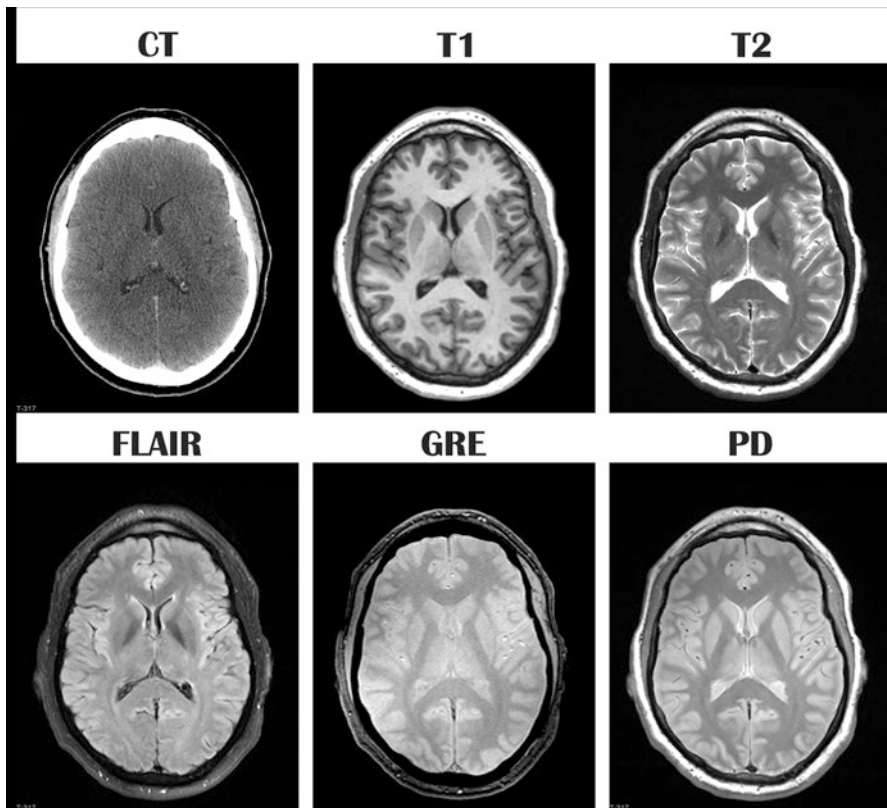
The images are all from the same individual and all performed at approximately the same level in a 45-year-old male control with no abnormalities. *CT* computed tomography, *T1* T1-weighted anatomical MRI with distinct white-gray matter boundaries, *T2* T2-weighted MRI where the hyperintense (white) signal indicates CSF or higher water content, *FLAIR* fluid-attenuated inversion recovery MRI sequence that is best in detecting abnormal white matter, *GRE* gradient-recalled echo that is particularly sensitive to blood by-products like hemosiderin but what is referred to as susceptibility-weighted imaging (SWI) shows even better detection for hemorrhage and associated findings, and *PD* proton density-weighted MRI also good at detecting pathology
